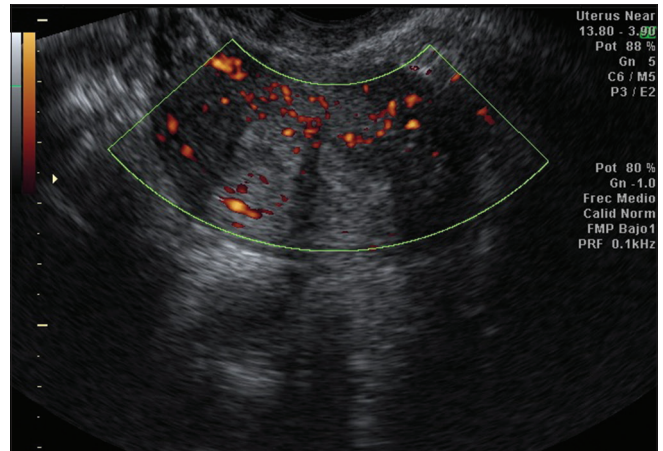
Doppler ultrasonography image showing a more intense Doppler signal in the right-sided uterus in comparison to the left one, meaning a higher frequency of subendometrial blood flow
